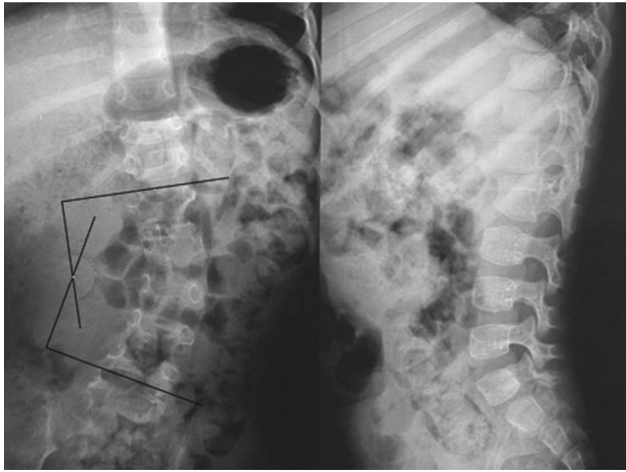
Face and profil late follow-up radiography confirms scoliosis (30° Cobb angle).
